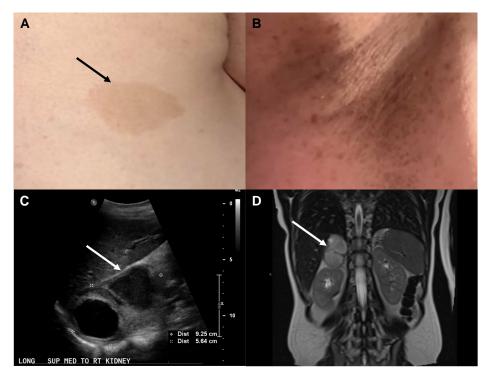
Unifying dermatologic and radiologic observations. On examination, the patient had café-au-lait macules (A) and axillary freckling (B). Ultrasound showed a 9-cm cystic right suprarenal mass (C), also identified on magnetic resonance imaging (D) as a mass with intermediate T2 hyperintense signal.
